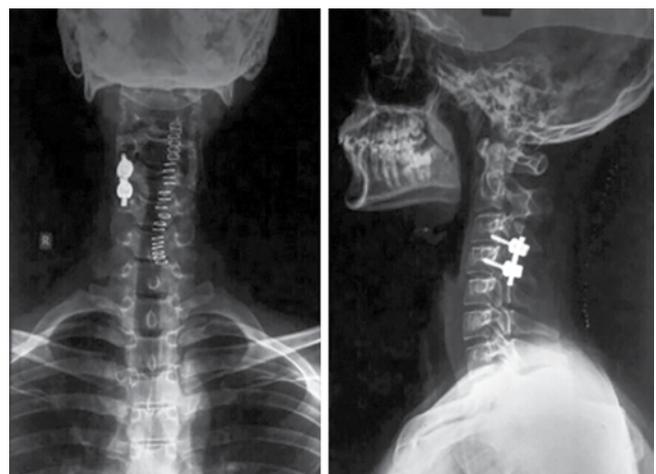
Postoperative X-ray showing fixation of cervical spine
